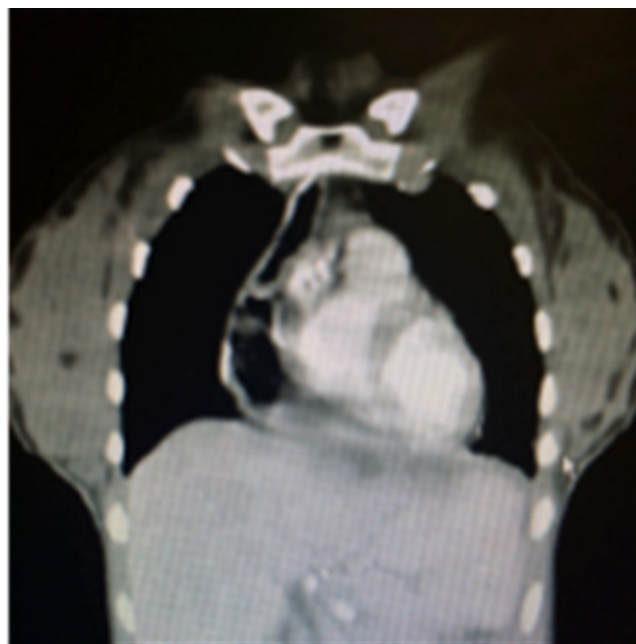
Computed tomography scan showing esophagocele.
